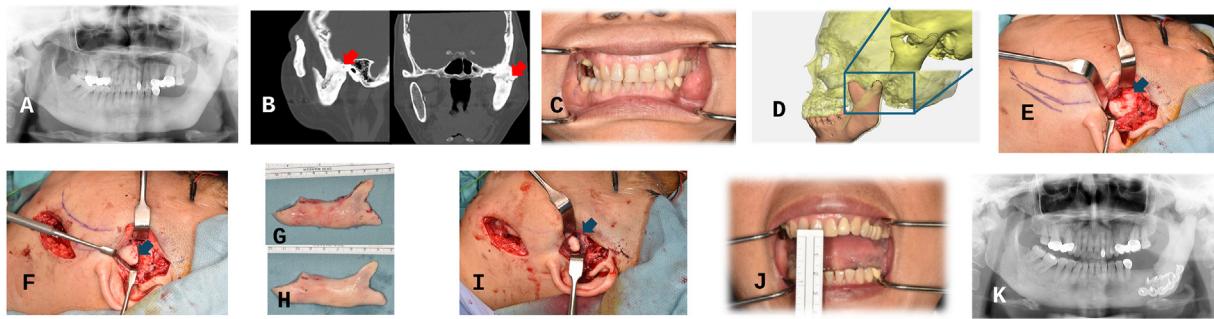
The radiographs, clinical photographs, and related photographs of our patient with the left mandibular fibrous dysplasia. (A and B) Ankylosis of the left mandibular condyle confirmed by the panoramic radiography and computed tomography scan. (C) Severe limitation of the mouth opening with the maximum mouth opening (MMO) of 0 mm. (D) Surgical treatment planned using the mirroring technique to identify the surgical separation site intraoperatively. (E) Intraoperative confirmation of ankyloses. (F) The ankylosed bone mass was surgically separated. (G) View of the separated mandibular condylar segment. (H) The segment was reshaped and modified. (I) The mandibular condylar segment was repositioned into its original anatomical location following cryosurgery with subsequent artificial disc replacement and anchorage. (J) Postoperative panoramic radiograph showing the left mandibular condyle at the correct position. (K) The MMO improved to over 25 mm at the one-month follow-up.
